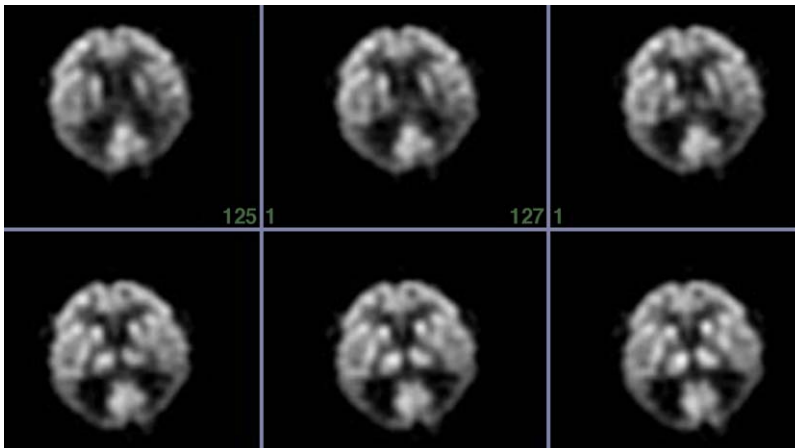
FDG-PET scan of a patient with moderately advanced Alzheimer’s disease. The findings demonstrate significant bilateral temporoparietal hypometabolism.
